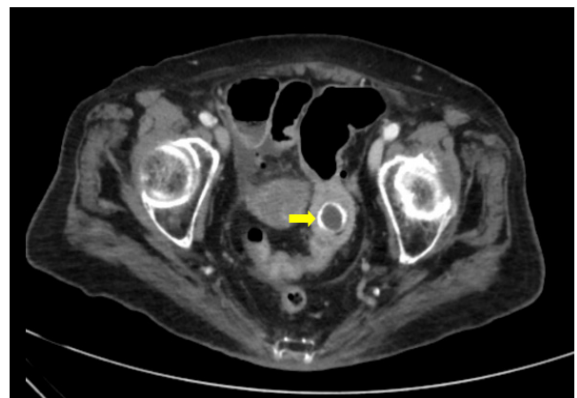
Abdominal and Pelvic CT showing a large gallstone in the rectosigmoid segment (arrow), leading to partial obstruction down to this level. CT: Computed Tomography.
